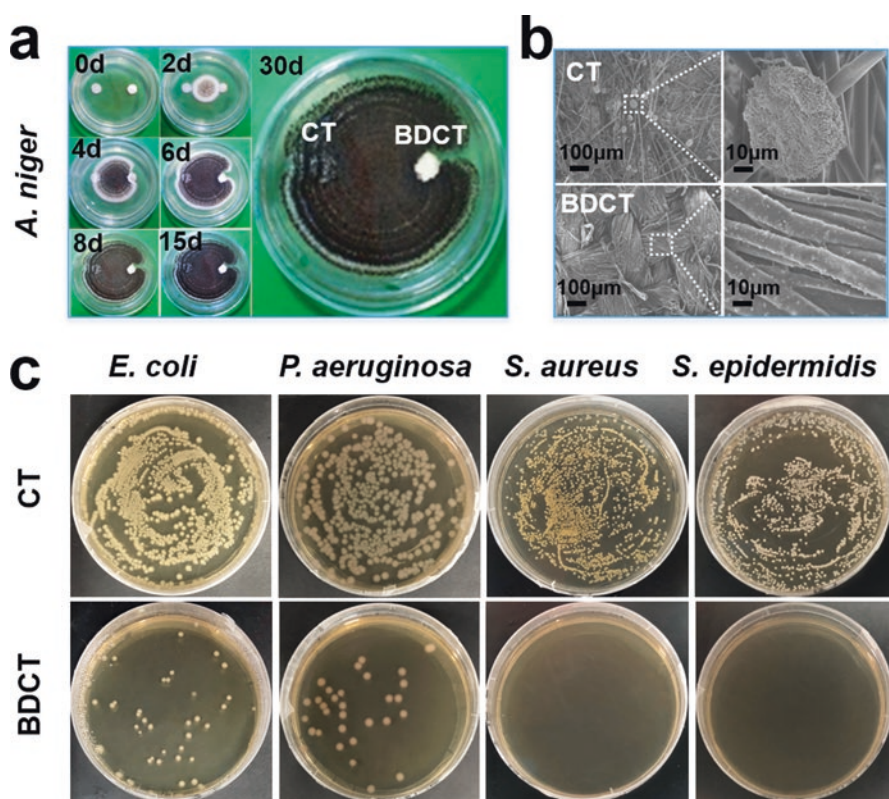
(a) Effect of antifungal adhesion on raw CT (left), and BDCT (right) by culturing *A. niger* in the center location of solid medium, in the same plate for different time periods (0, 2, 4, 6, 8, 15, and 30 days). (b) SEM images of antifungal adhesion results on raw CT and BDCT surfaces. Left are images at low magnifications; right are images at high magnifications. (c) Antibacterial activities of raw control CT and BDCT against *E. coli*, *P. aeruginosa*, *S. aureus*, and *S. epidermidis* [62]
